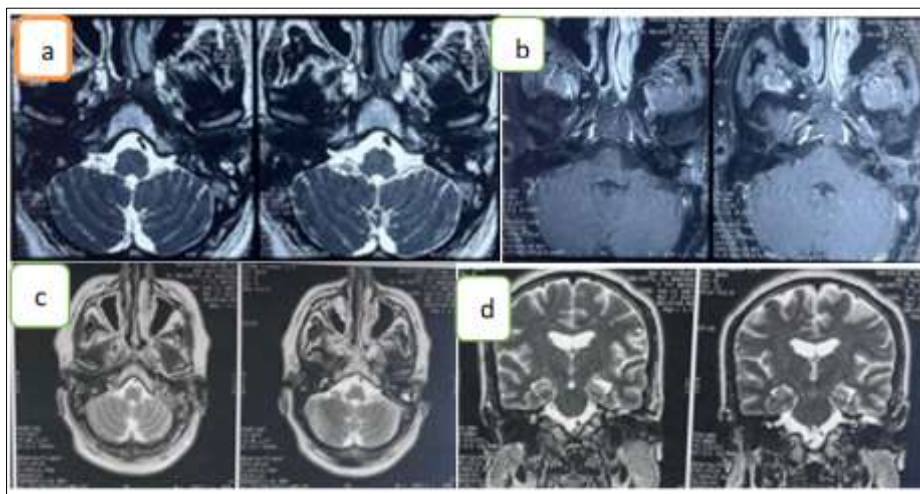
T2-weighted sequence: CISS in axial cut (a), axial T1 cut after gadolinium injection (b), and T2 sequence in axial and coronal cuts showing a postoperative evacuation cavity, well-aerated on the left, with T2 hyperintensity and no pathological contrast enhancement No signs of recurrence
